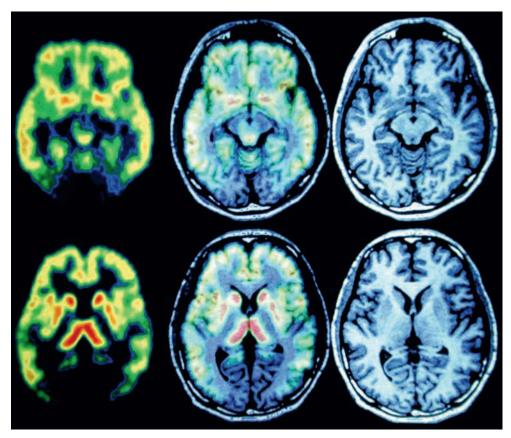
Images of C¹¹Buprenorphine binding on PET (*left*) and MRI images of the same brain (*right*) with fused images shown in the *centre*. (Courtesy of Dr A Jones, Hope Hospital, Salford, UK)
